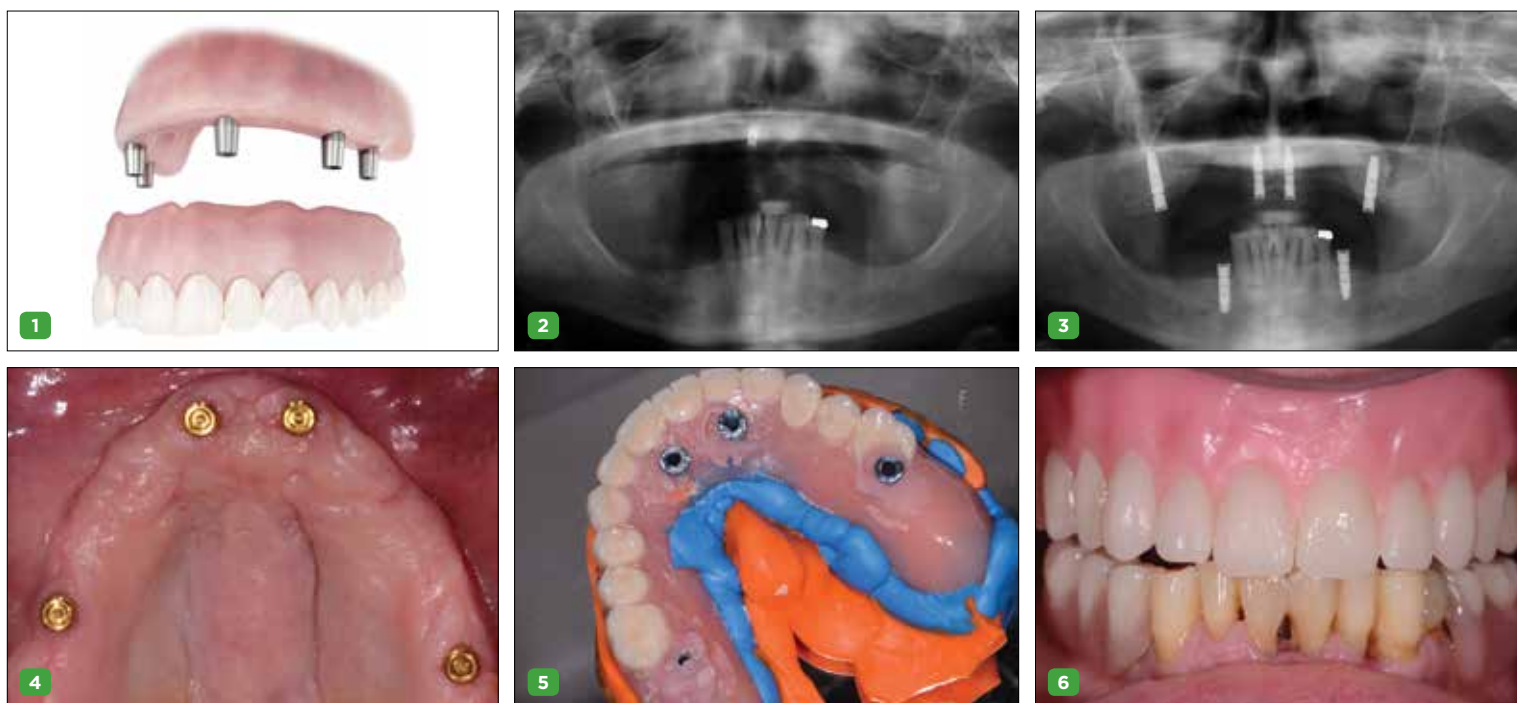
A friction-retained hybrid prosthesis. Fig 2. Pre-operative x-ray shows the failed implants. Fig 3. Post-operative x-ray shows the new implants. Fig 4. A locator-supported denture is fabricated. Fig 5. The patient's prior denture is used for bite and impression. Fig 6. Wax-based tooth try-in is used.
